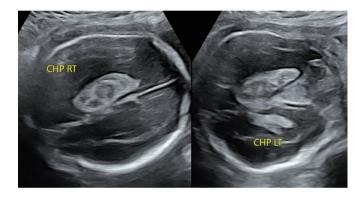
Prenatal ultrasound scan at 27 weeks demonstrating bilateral ventriculomegaly (right choroid plexus, left choroid plexus).
